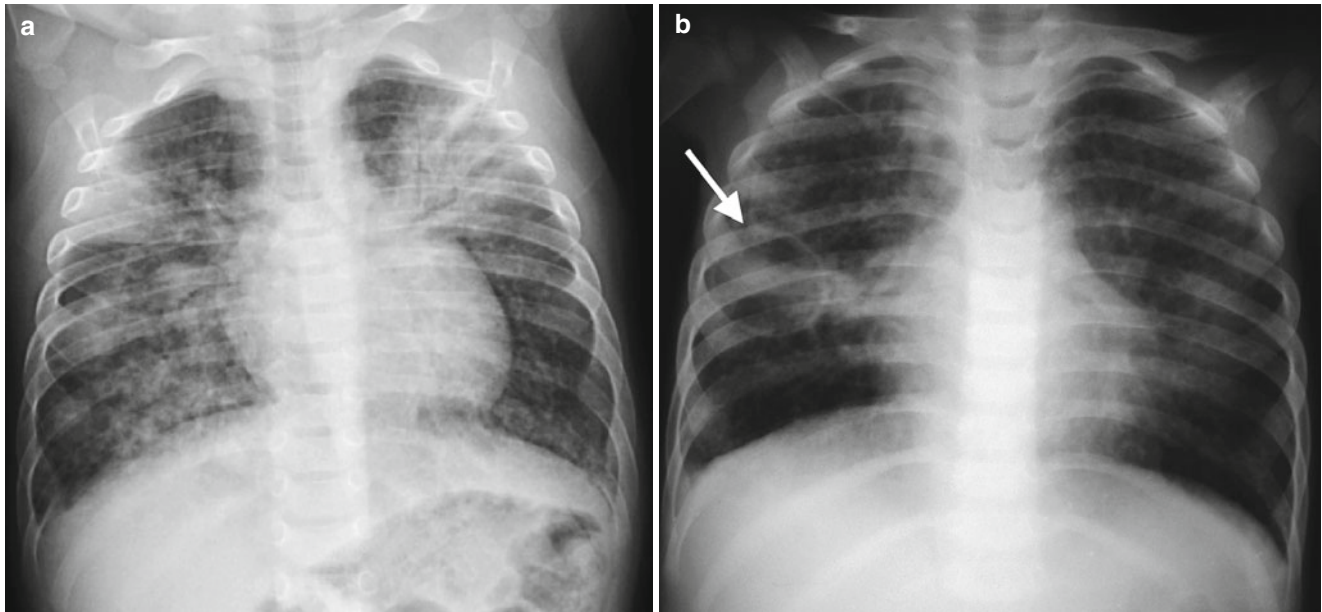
Pneumocystis jiroveci* infection. Radiograph of a 10-month-old boy diagnosed with severe combined immune deficiency syndrome showing diffuse reticulonodular interstitial pattern in both lungs with development of lung consolidations (a). Radiograph of a 14-month-old
